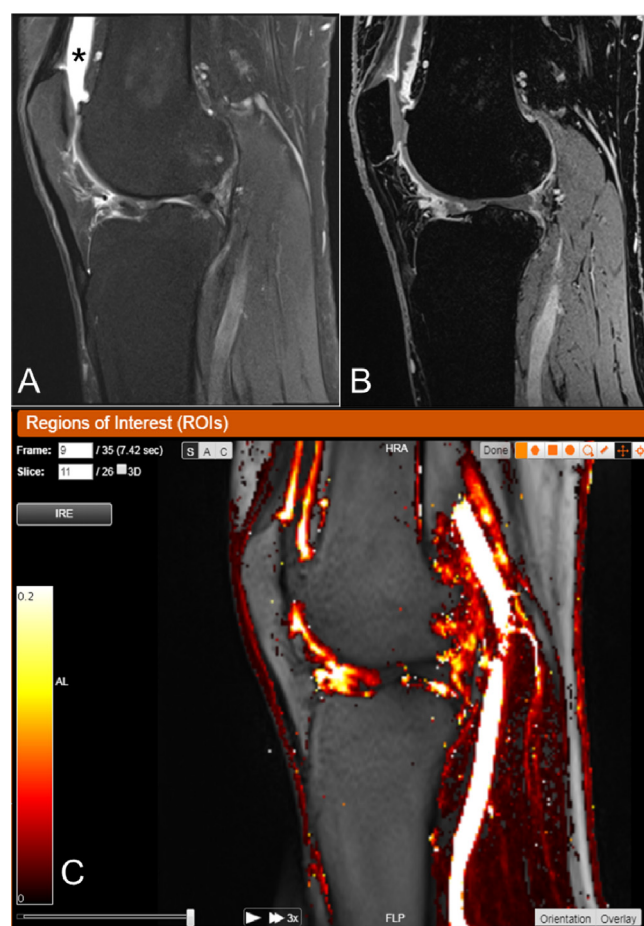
Magnetic resonance imaging (MRI) of synovitis and effusion in knee osteoarthritis. These images were acquired from the same patient as in Figs. 1 and 2. A) Proton density weighted sagittal image through the mid-part of the knee, showing moderate effusion/synovitis in the suprapatellar pouch in the upper part of the image (*) as well as an increased signal intensity in Hoffa's fat pad. B) Post contrast gradient echo 3D VIBE sequence with fat saturation, showing increased enhancement of an irregular thickened synovium of the suprapatellar pouch. Note the hypointense area inside the enhancing synovium which corresponds to effusion, the enhancing synovium on the inside of Hoffa's fat pad and the slight enhancement in the posterior capsule. C) Dynamic contrast enhanced MRI with the color map of the initial rate of enhancement, the most severe inflammation is shown in white-bright yellow and lower degrees of inflammation in red colors. The image shows spotted areas of high perfusion in the synovial membrane in the suprapatellar pouch, high uniform enhancement of the synovium covering Hoffa's fat pad and slow enhancement in the posterior capsule. This reflects different perfusion patterns of the various tissues that could serve as specific inflammatory phenotype profiles.
